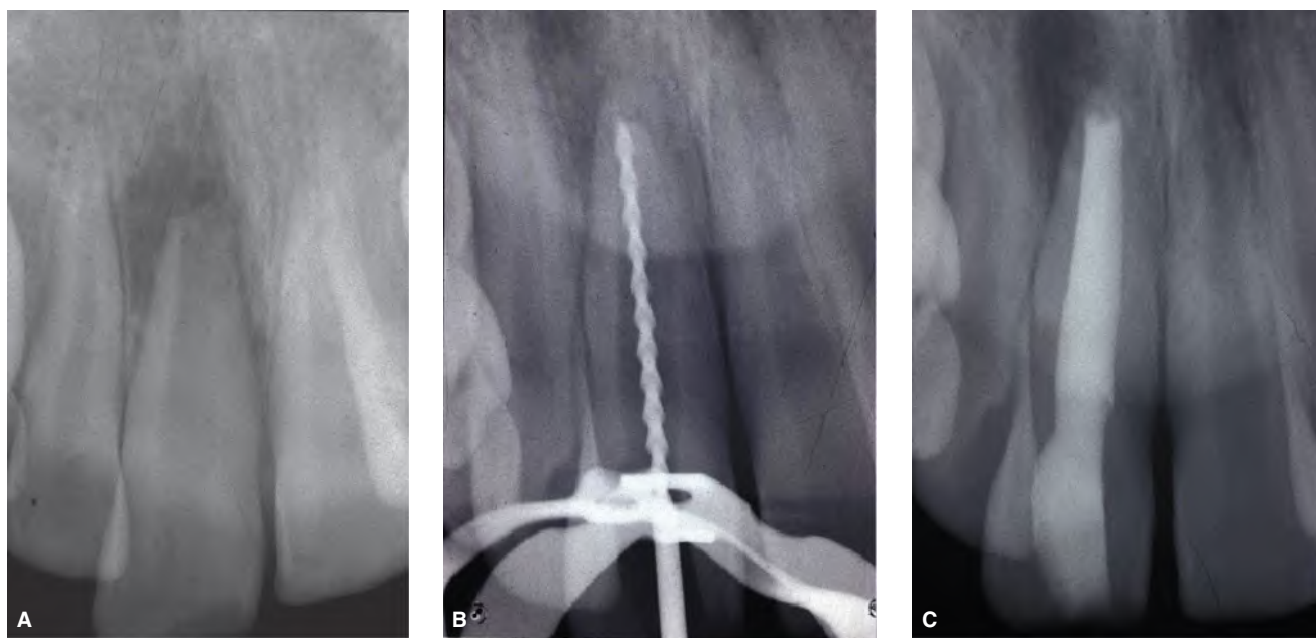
Apexification with calcium hydroxide. A. Maxillary central incisor with a history of crown fracture and subluxation. The pulp was infected and necrotic and there was an apical lesion of endodontic origin. The canal was cleaned and disinfected and a preparation of calcium hydroxide placed. B. Radiograph taken 3 months later showing a file used to test the presence of an apical barrier (apexification). C. The root canal was obturated with gutta-percha and sealer. The tooth was asymptomatic and the patient monitored for continued healing. (Courtesy of the Endodontic Clinic, Loma Linda University, School of Dentistry, CA.)
